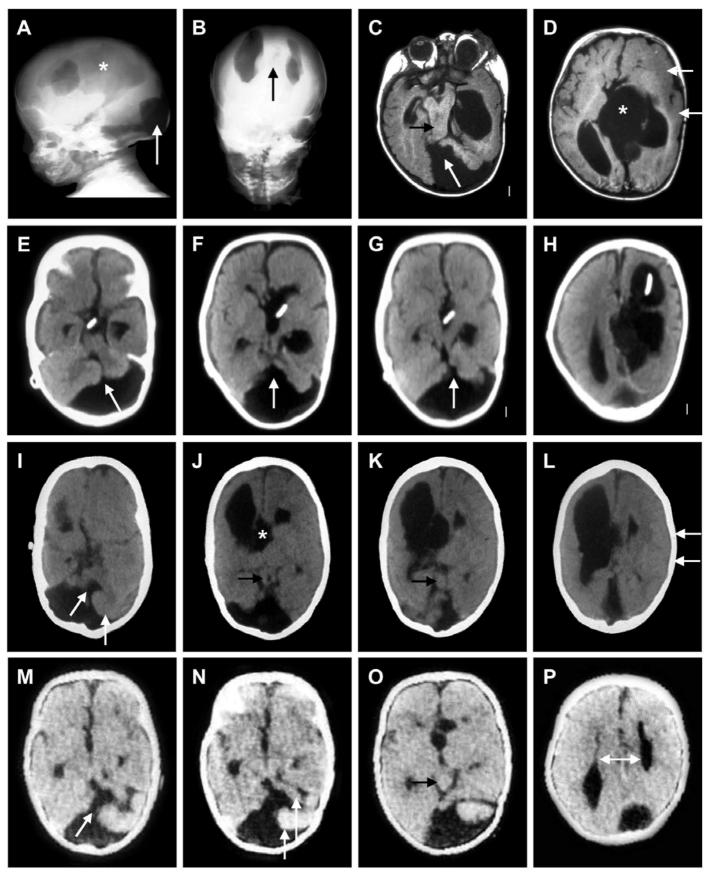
The classical OCCS brain malformation. Lower resolution brain imaging studies in four other patients showed similar changes. These consisted of a pneumoencephalogram in patient 8 (A-B), two images from an MRI in patient 5 (C-D), and cranial CT scans in patients 5 (E-H), 6 (I-L) and 7 (M-P). Images through the cerebral hemispheres in patients 5 and 6 show loss of the normal gyral pattern and moderately thick cortex (white arrows in D and L) that
